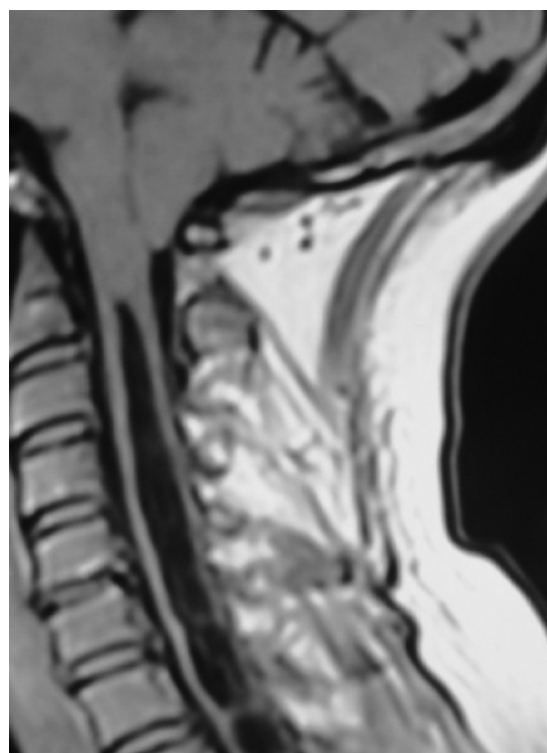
MRI showing chiari I with syrinx
